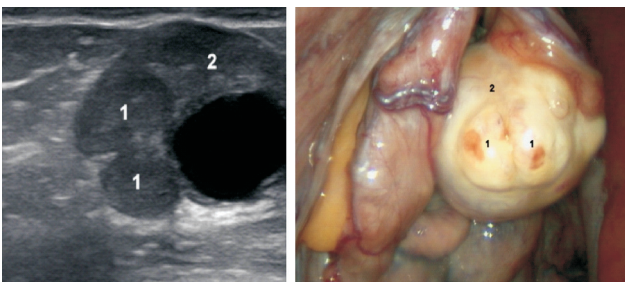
Ovarian abscess on ovary. (a) Ultrasound image (b) Laparoscopic image.
